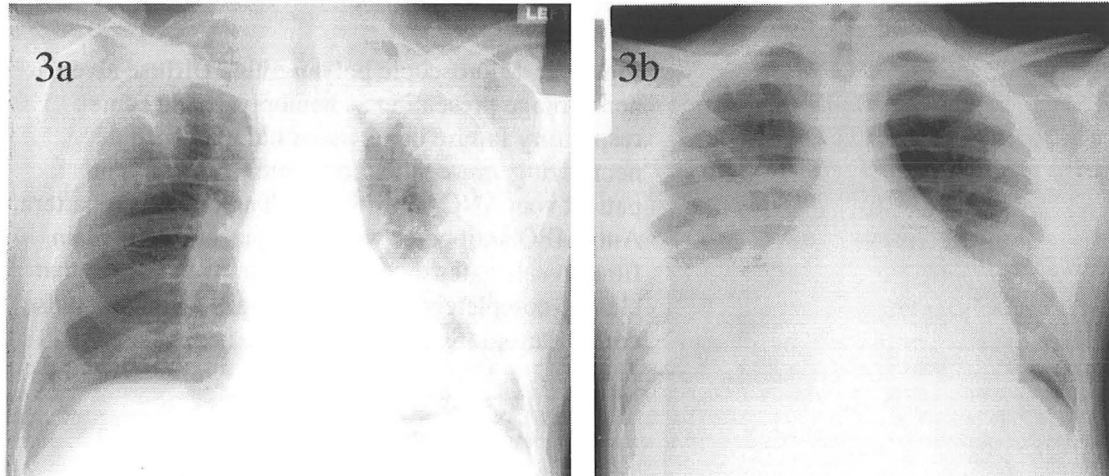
Plain chest radiographs in two patients with Churg Strauss syndrome. 3a) peripheral, axillary predominant consolidation, a finding classic for chronic eosinophilic pneumonia, that is sometimes also seen in CSS. 3b) chest film of a patient with a two year history of asthma and long-standing allergic rhinitis with nasal polyposis. He presented with dyspnea, orthopnea, abdominal pain and marked eosinophilia. He had a pericardial effusion, an ejection fraction of 35%, mononeuritis multiplex, and bilateral, basilar predominant airspace disease with eosinophilic pneumonia (but no vasculitis) by surgical lung biopsy.
